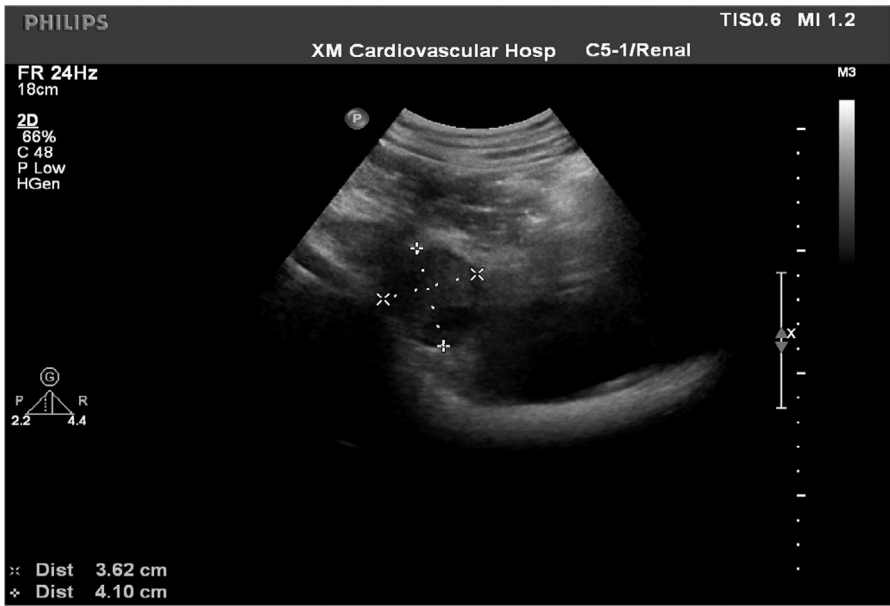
Ultrasonography of the left adrenal gland showing a substantial hypoechoic mass with clear boundary. Size: 3.62×4.10 cm.
